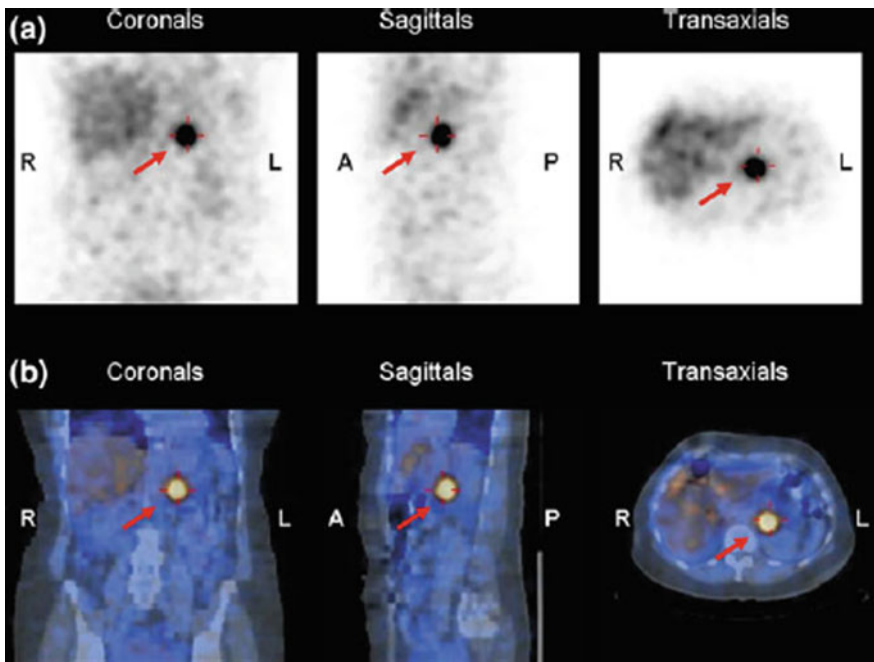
SPECT images a and SPECT/CT overlay b of a patient with a neuroendocrine tumor (pheochromocytoma) in the upper thorax. Accumulation of [^{123}I]MIBG in the malignant tissue is indicated with red arrows. The images have been kindly provided by N. Schäfer, (MD, Ph.D.), University Hospital, Zurich, Switzerland
